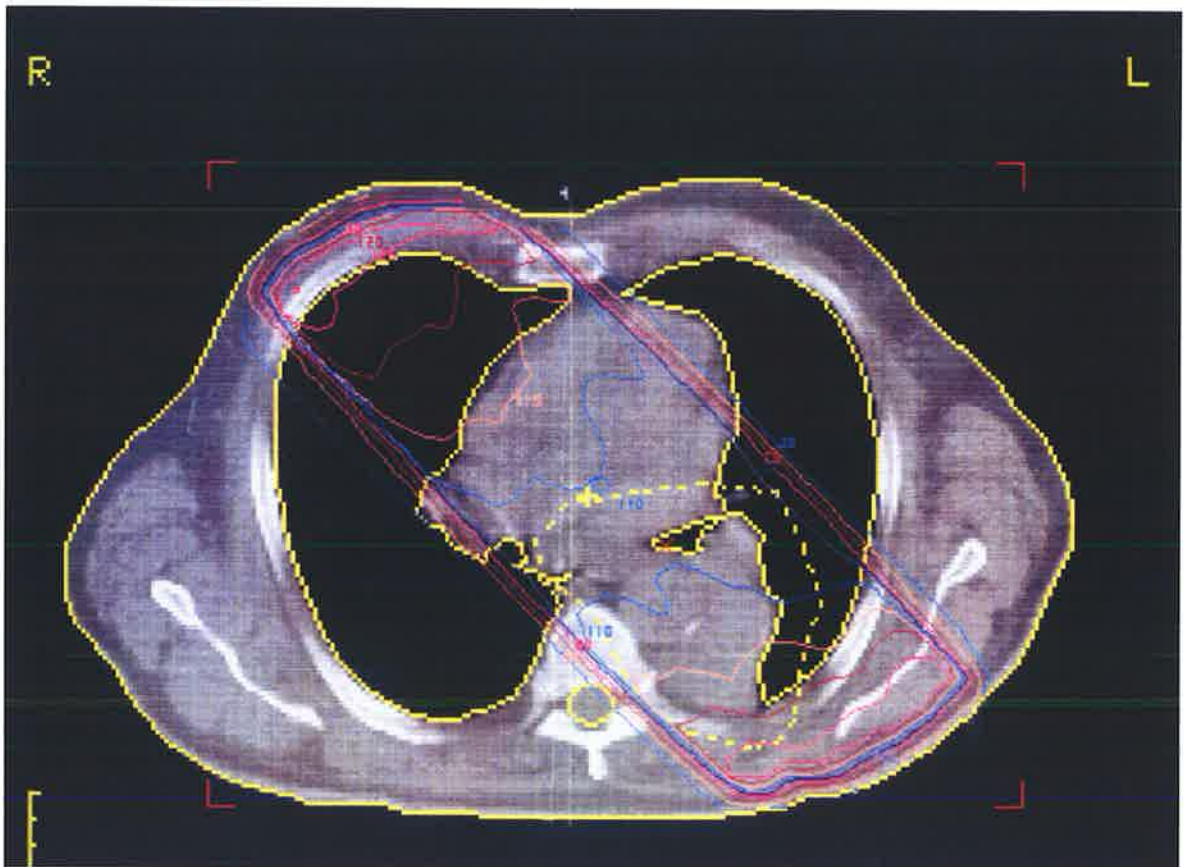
Central axis planning CT image with target volume indicated by interrupted yellow line. The isodose plot for a pair of parallel opposed obliques angled to avoid spinal cord is superimposed.
